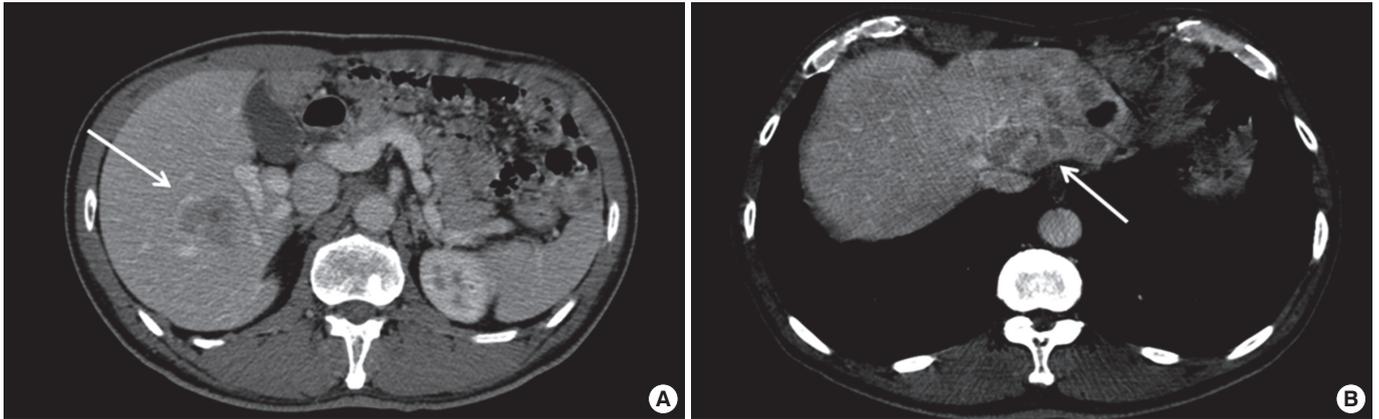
Computed tomography of the abdomen after 15 months since surgery. It showed multiple hepatic metastases, medium-sized and small nodules in the (A) right (arrow) and (B) left (arrow) hepatic lobes.
